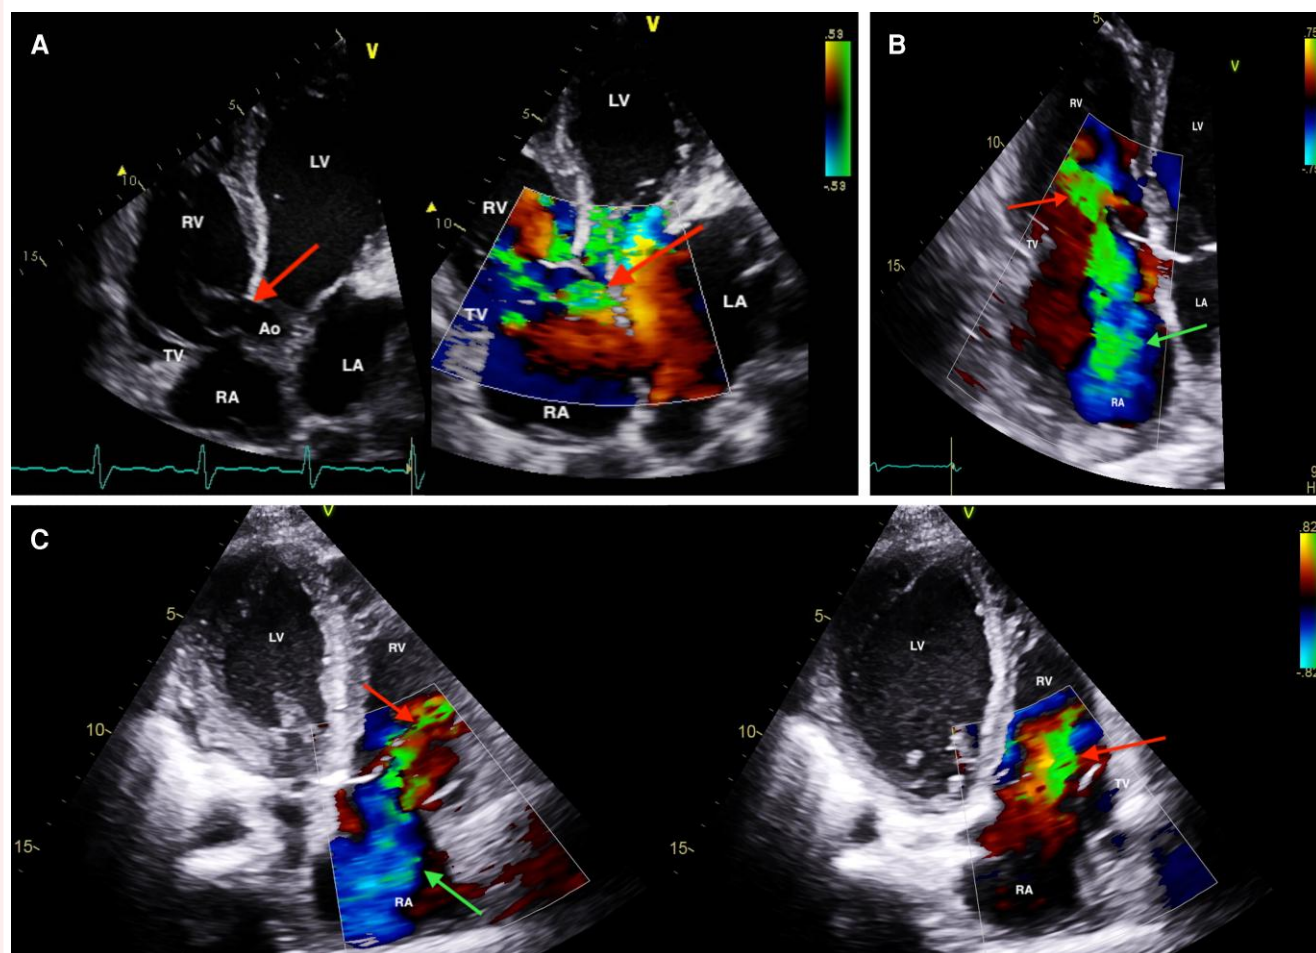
Transthoracic echocardiographic images. Apical five-chamber view (A) demonstrating a ruptured sinus of Valsalva aneurysm in close proximity to septal tricuspid valve leaflet insertion (left) with colour flow through the defect into the tricuspid valve (right). Apical four-chamber view (B) exhibiting bidirectional systolic flow through the tricuspid valve with moderate–severe tricuspid regurgitation. Reverse apical four-chamber view (C) shows bidirectional systolic flow (left) and high-velocity diastolic forward flow through the tricuspid valve (right). RV, right ventricle; LV, left ventricle; TV, tricuspid valve; Ao, aorta; RA, right atrium; LA, left atrium; red arrow, RSOVA and/or RSOVA flow; green arrow, tricuspid regurgitation; RSOVA, ruptured sinus of Valsalva aneurysm; TR, tricuspid regurgitation.
